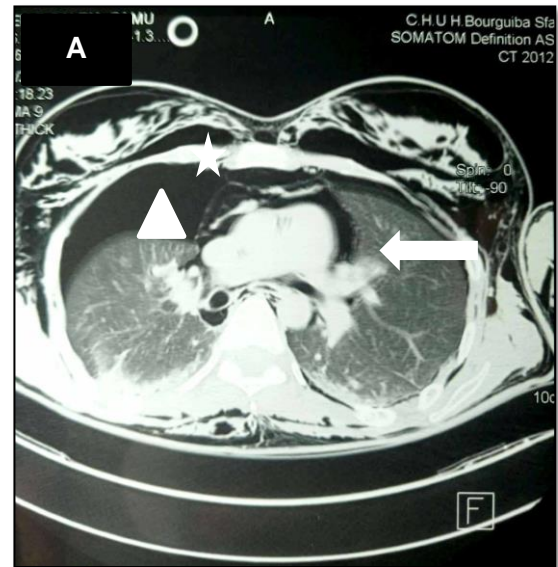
The CT scan showing a pneumomediastinum (Triangle) with a pneumopericardium (arrow) with an important emphysema (star) in axial (A) and sagittal (B) plans
